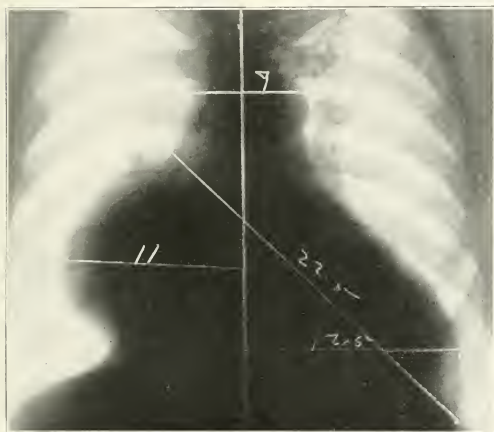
Seven foot roentgenogram of the chest made at the time of the second admission, March, 1920.
